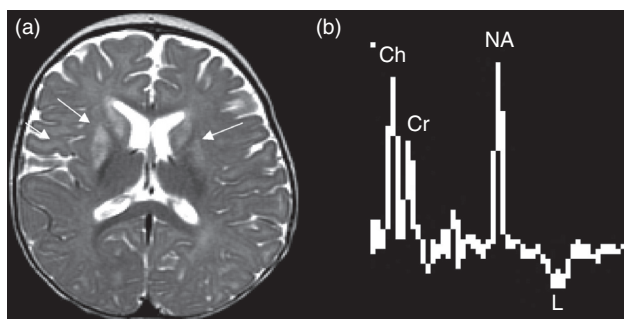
Leigh syndrome with basal-ganglia lesions (arrows) and white-matter involvement: (a) axial T2 MRI; (b) lactate doublet (L) on MRS.
